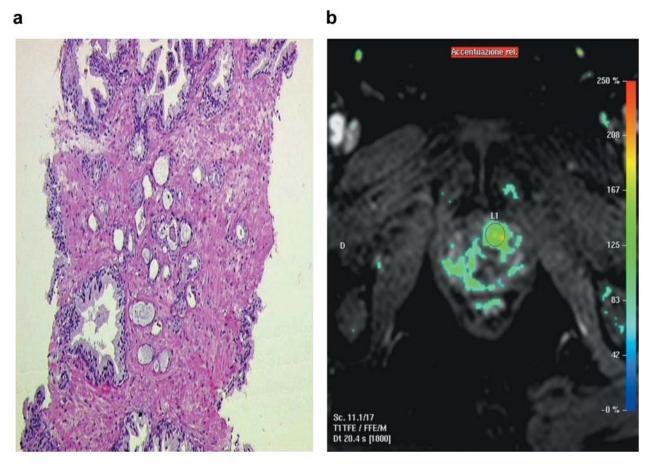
A 67-year-old man with an initial biopsy showing a microfocus of prostate cancer (a) submitted to multi-parametric pelvic MRI (b) that demonstrated a lesion (diameter of 12 mm) suspicious for cancer of the anterior zone of the gland. MRI-targeted biopsy detected 3 cores of Gleason score 6 with a greatest percentage of cancer equal to 50%.
